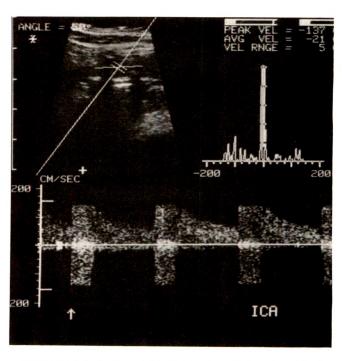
Duplex sonogram of internal carotid artery (ICA) just distal to moderate (60–80%) stenosis shows considerable aliasing, with peak velocity (including aliased portion) summated to 270 cm/sec. There is considerable spectral broadening, but end-diastolic velocity is less than 100 cm/sec.
